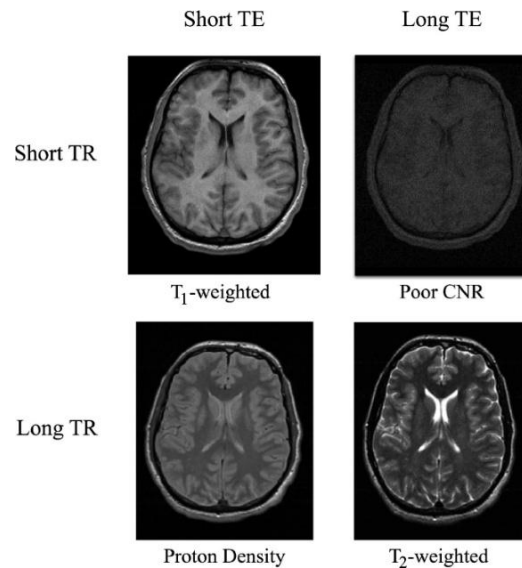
MRI contrast influenced by the balance of the TR and TE: For T1-weighted images (top left, short TE and short TR), cerebrospinal fluid appears dark, and white matter is brighter than grey matter. For proton density images (bottom left, short TE and long TR), the contrast highlights proton density with moderate grey and white matter differentiation. For poor contrast-to-noise ratio (CNR) images (top right, long TE and short TR), there is a reduced tissue differentiation. For T2-weighted images (bottom right, long TE and long TR), cerebrospinal fluid appears bright, and white matter is darker than grey matter. (from [118])
